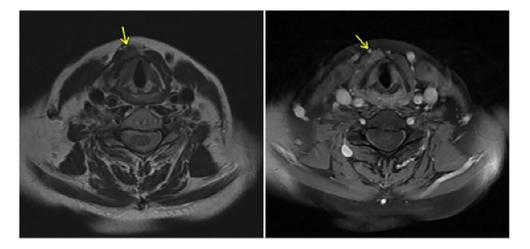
MRI of the neck displaying increased uptake in the sternothyroid muscle.
